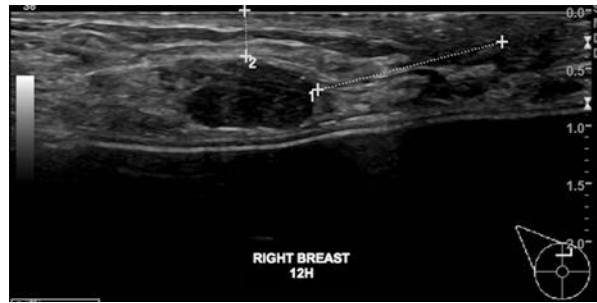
Isoechoic mass that is difficult to characterize in B mode (a), but well delimited with the use of power Doppler (b)
